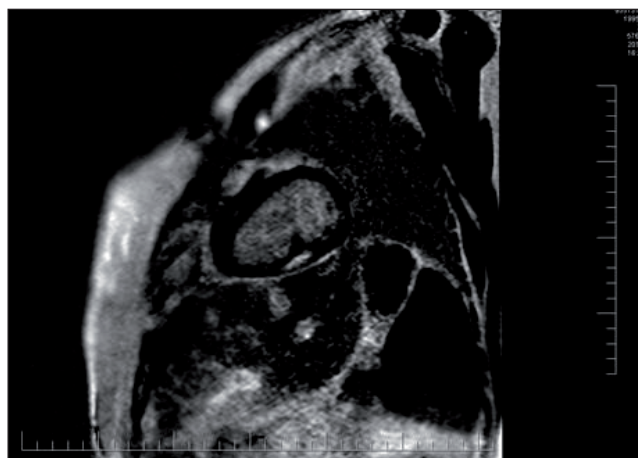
Cardiac magnetic resonance imaging (MRI), the late gadolinium enhancement showed the signs of past inferior transmural ischemia.
